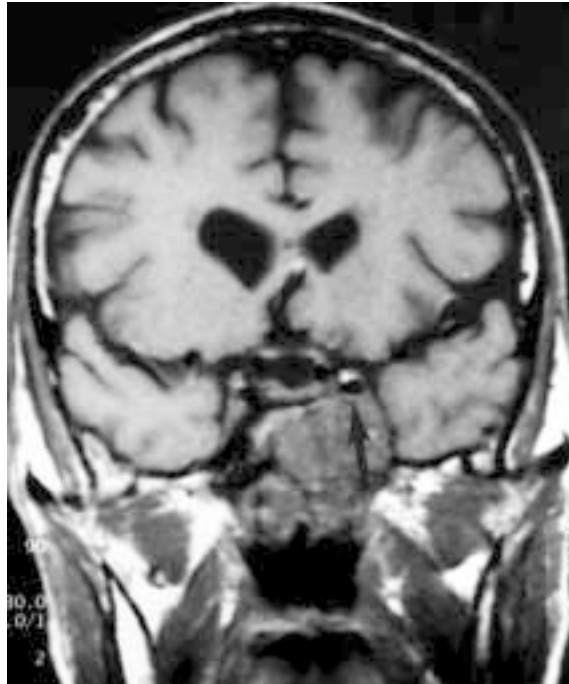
Coronal T1-weighted MR image of a 68-year-old Caucasian man who presented with visual disturbance and intermittent airway obstruction for 16 weeks. The isointense mass that has partially destroyed the clivus and extended into the left cavernous sinus to partly encase the cavernous internal carotid artery (arrow). The tumour has also encroached on the nasopharynx. At surgery, 75% of the chordoma was removed.
